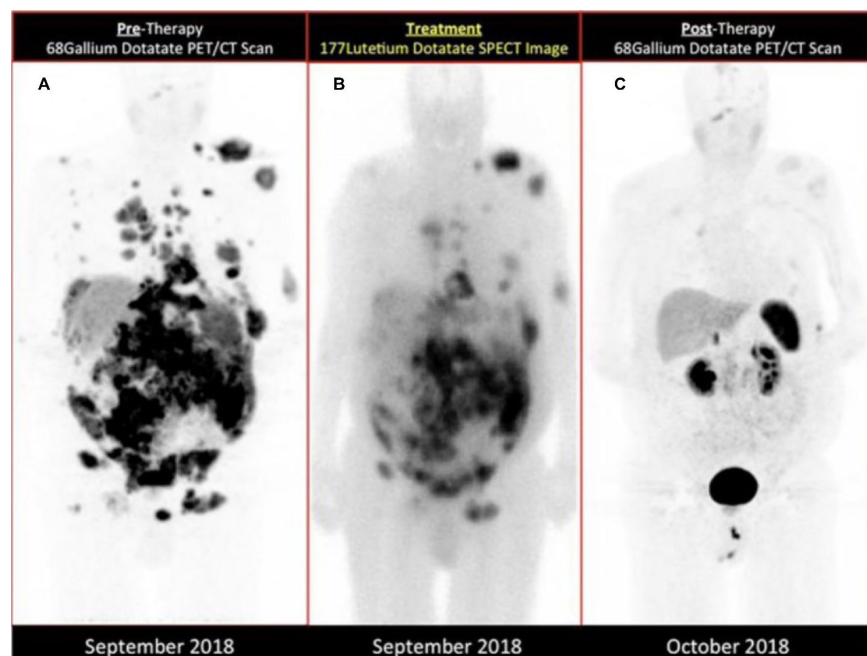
Dramatic improvement in a patient refractory to anti-PD-L1 (avelumab) receiving a single off-label dose of ^{177}Lu -DOTATATE for heavily metastatic Merkel cell carcinoma and resuming avelumab. (A) Pre-treatment ^{68}Ga -DOTATATE PET/CT scan, (B) ^{177}Lu -DOTATATE SPECT/CT scan during TRT, and (C) ^{68}Ga -DOTATATE PET/CT scan 1 month post-treatment. Image reproduced from Kasi et al, 2019.
